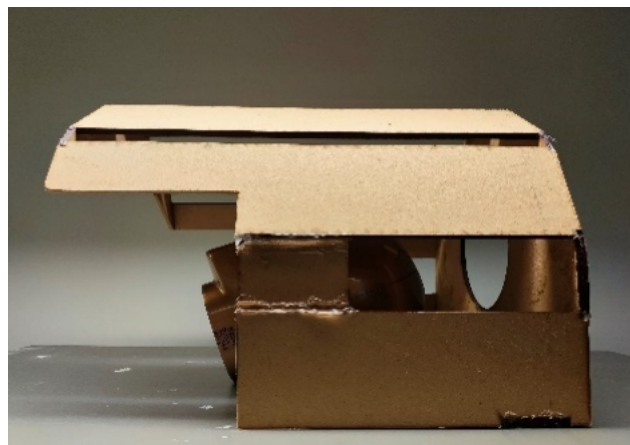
The wooden coil holder used in the MRI scan to hold the body coil with a head model with a brown color inside it with a neutral posture.
